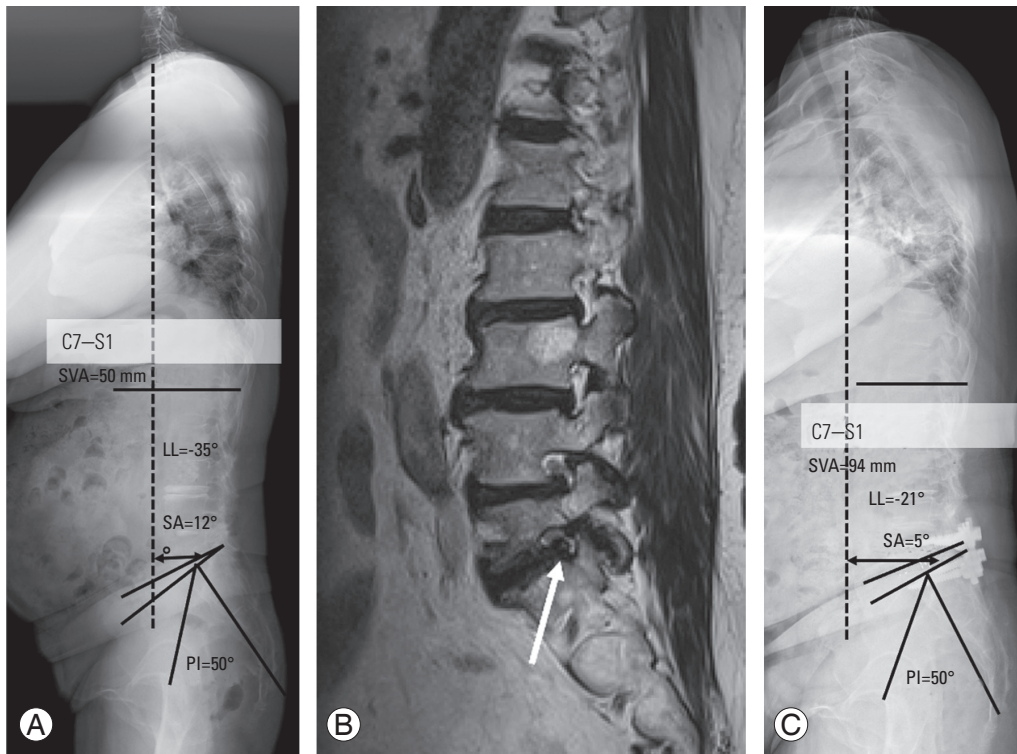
A representative case showing the aggravation of sagittal balance following posterior lumbar interbody fusion at L5–S1 level with 8° lordotic cages. (A) A 68-year-old female patient with left leg sciatica and intermittent claudication showed regional sagittal imbalance preoperatively. (B) Magnetic resonance imaging showed left foraminal stenosis at L5–S1 level (arrow). (C) Regional sagittal parameters did not improve in the 2-year postoperative radiograph, despite the use of 8° cages. SVA, sagittal vertical axis; LL, lumbar lordosis; SA, segmental angle; PI, pelvic incidence.
